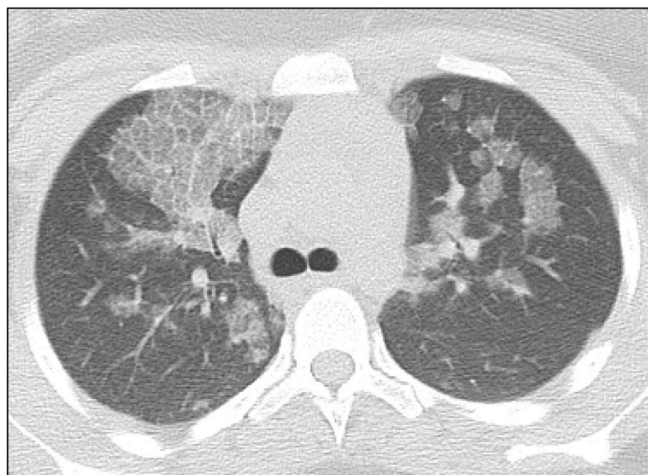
Axial CT chest scan demonstrating the "crazy paving" pattern.
